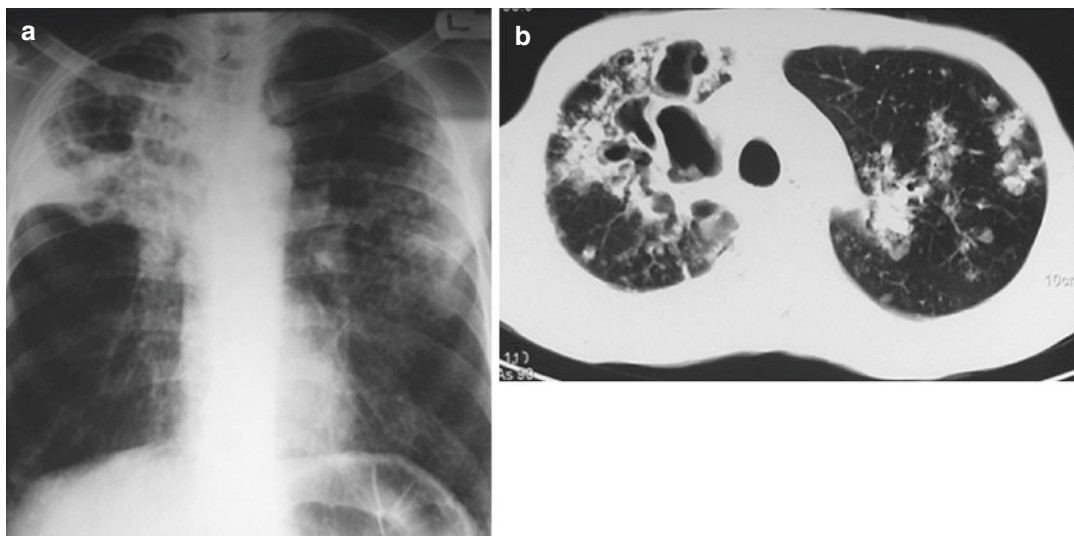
Reactivated pulmonary TB. (a) Frontal chest radiograph shows typical location of TB involvement in *right* upper lobe with cavitary consolidation and volume loss. There are also some nodular opacities in *left* upper
